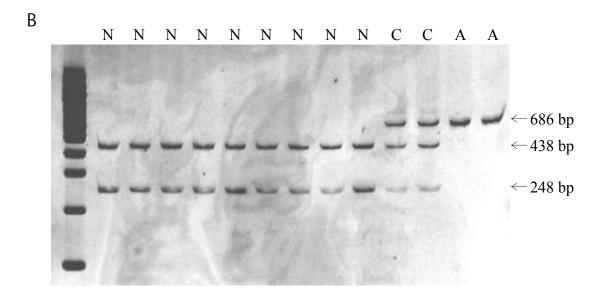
Detection of L276I in FKRP. (A) Electropherogram of sequence from exon 4 of FKRP showing the L276I mutation. The upper sequence was obtained from an unaffected individual and the lower from an affected individual. The mutation changes a Leu codon (CTA) to an Ile codon (ATA). (B) Assay for L276I based on a natural BfaI site (CTAG) abolished by the change. The full length fragment is 686 bp and when the site is present, BfaI digestion will produce 438 bp and 248 bp fragments. N = homozygous L276, C = heterozygous, A = homozygous L276I. Individuals shown were randomly selected, in all cases L276I segregates with the disease phenotype.
